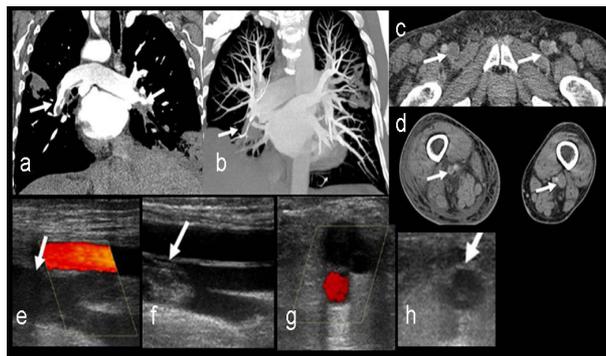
Case 1. A. Emboli in the right and left branches of pulmonary artery (arrows) in the coronal curved MIP reformatted images B. Embolus in the right descending branch of pulmonary artery in coronal MIP reformatted images C. Filling defects in bilateral main femoral veins (arrows) in indirect CTV and popliteal veins D. (arrows) E. Absence of flow in the right femoral vein in Doppler (arrow) F. Echogenic thrombus in the left main femoral vein (arrow) G. While flow can be seen in right popliteal artery, hypoechoic thrombi are evident in right popliteal vein G. and left popliteal vein H. lumens.
